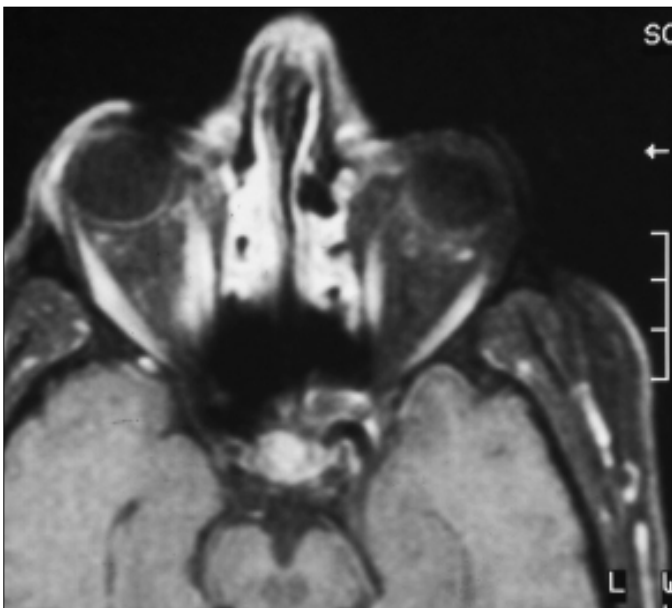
Magnetic resonance imaging of case-2 showed extraocular muscle enlargement consistent with Graves' ophthalmopathy
